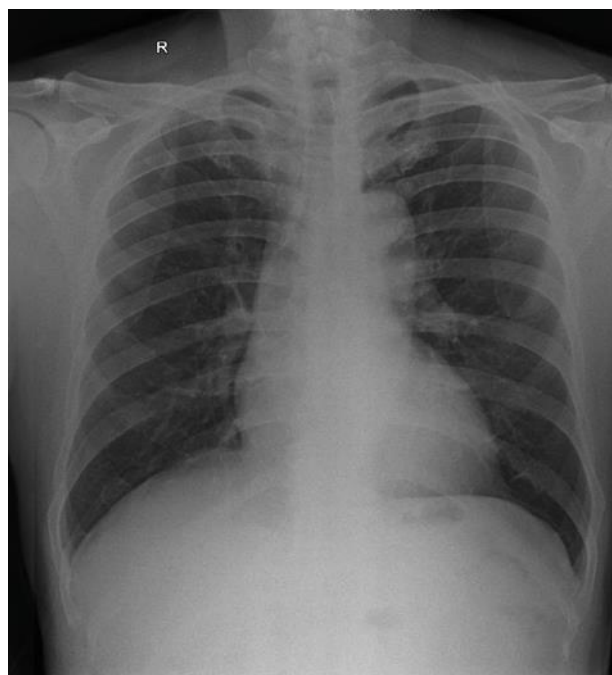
Chest x-ray during re-evaluation on 17 January 2022 (showed perihilar bronchitis, normal heart size, improvement of abnormality based on previous x-ray)
